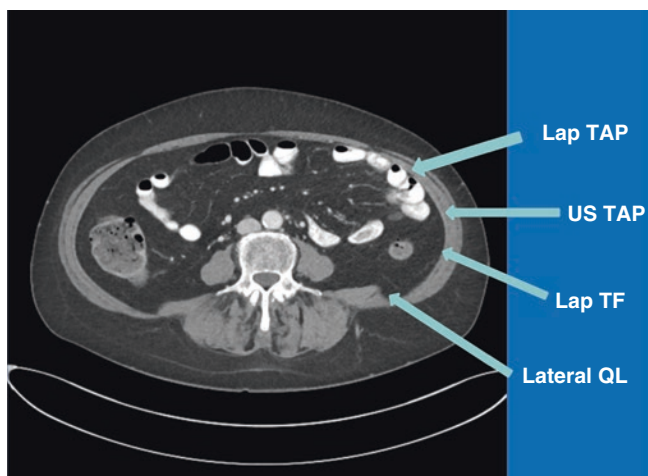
Fascial planes for blocks: Lap TAP, US TAP, LAP TF, lateral QL. Lap laparoscopic, TAP transversus abdominis plane, US ultrasound, TF transversalis fascia, QL quadratus lumborum
